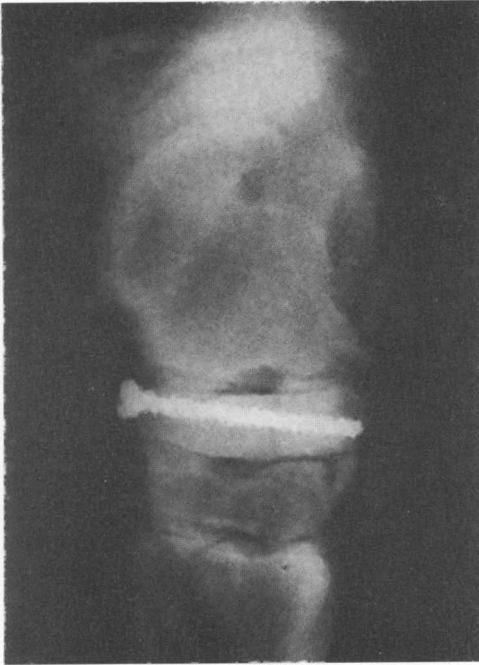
Radiograph (125°, PDLMO) of a plantar slab fracture of the central tarsal bone. In this case a 48 mm long 4.5 mm cortical screw was used in order to stabilize the fracture.
